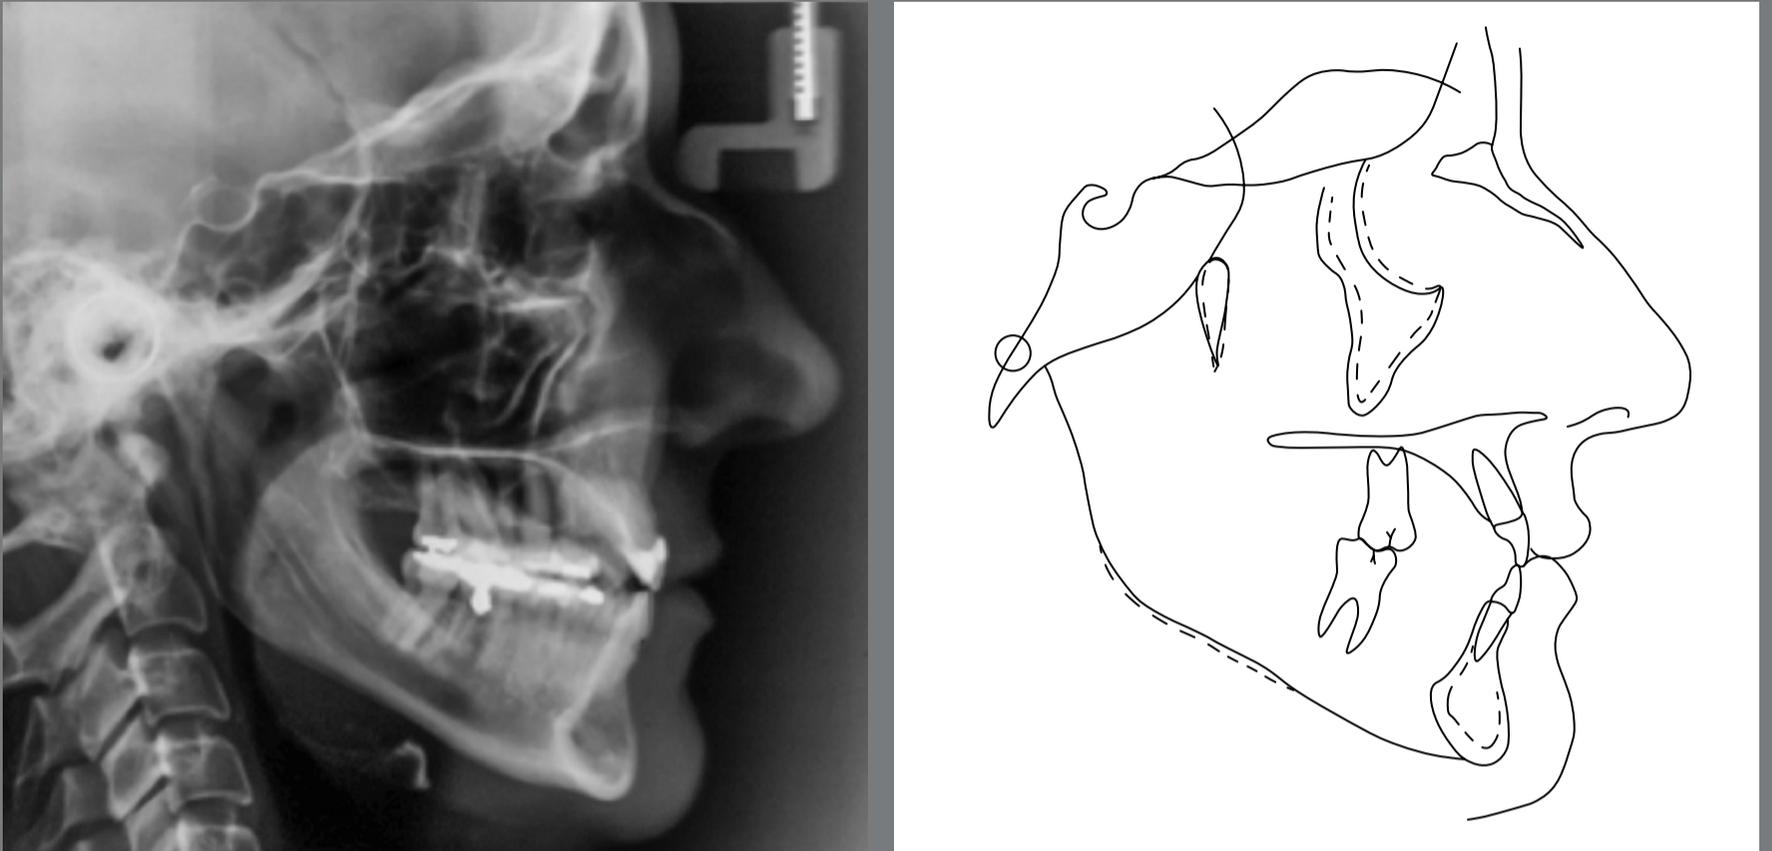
Baseline cephalometric radiograph and cephalometric tracing.
